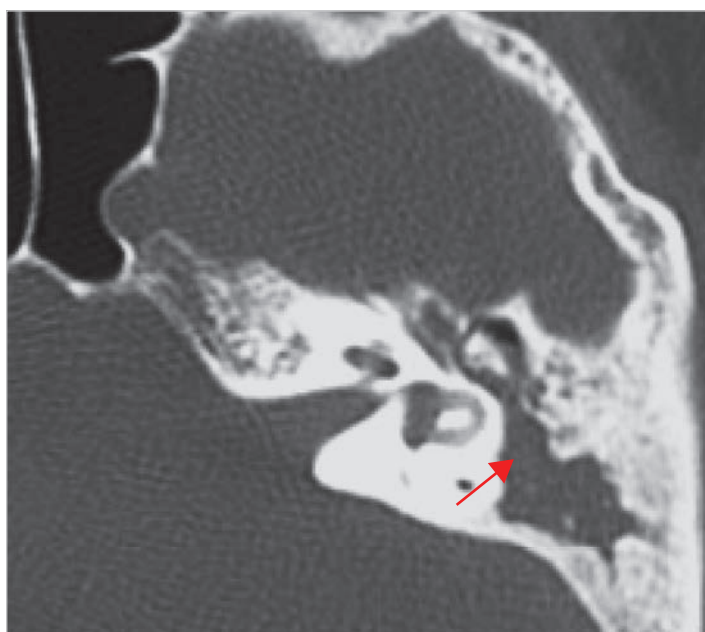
CT scan of the same case, axial view. The cholesteatoma extends posteriorly toward the antrum and the mastoid (arrow). However, some of the opacification may be effusion and scar tissue. Incapability to discriminate soft tissue is one of the drawbacks of CT examination.
